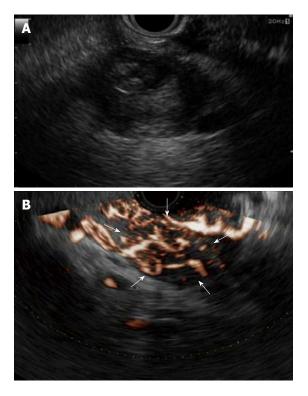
Neuroendocrine tumor. A: EUS shows a heterogeneous appearance; cystic, with a solid component or pure fluid 31 mm in diameter; B: EUS using Doppler mode shows a hypervascular mass at the tail of the pancreas (arrows).
